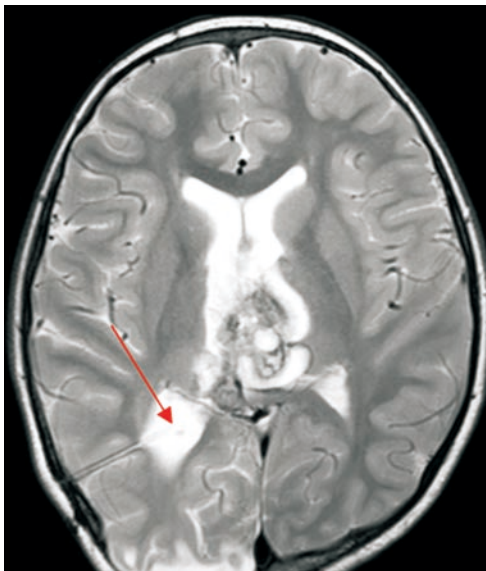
T2 weighted MRI image in axial view post VP shunt placement through the right temporal region. The tip within the occipital horn of the right ventricle is shown by red arrow. There is a reduction in hydrocephalus.
